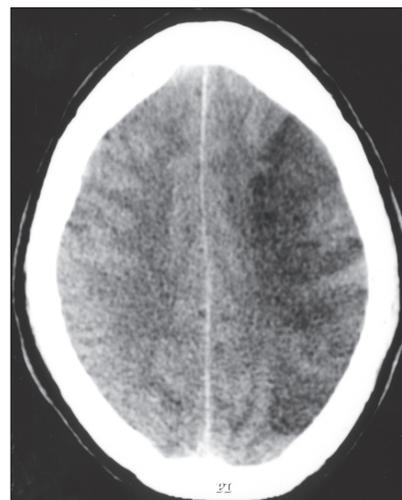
Brain CT (axial non-contrast) showing huge left middle cerebral artery stem infarct involving frontotemporo-parietal lobe with mass effect.
